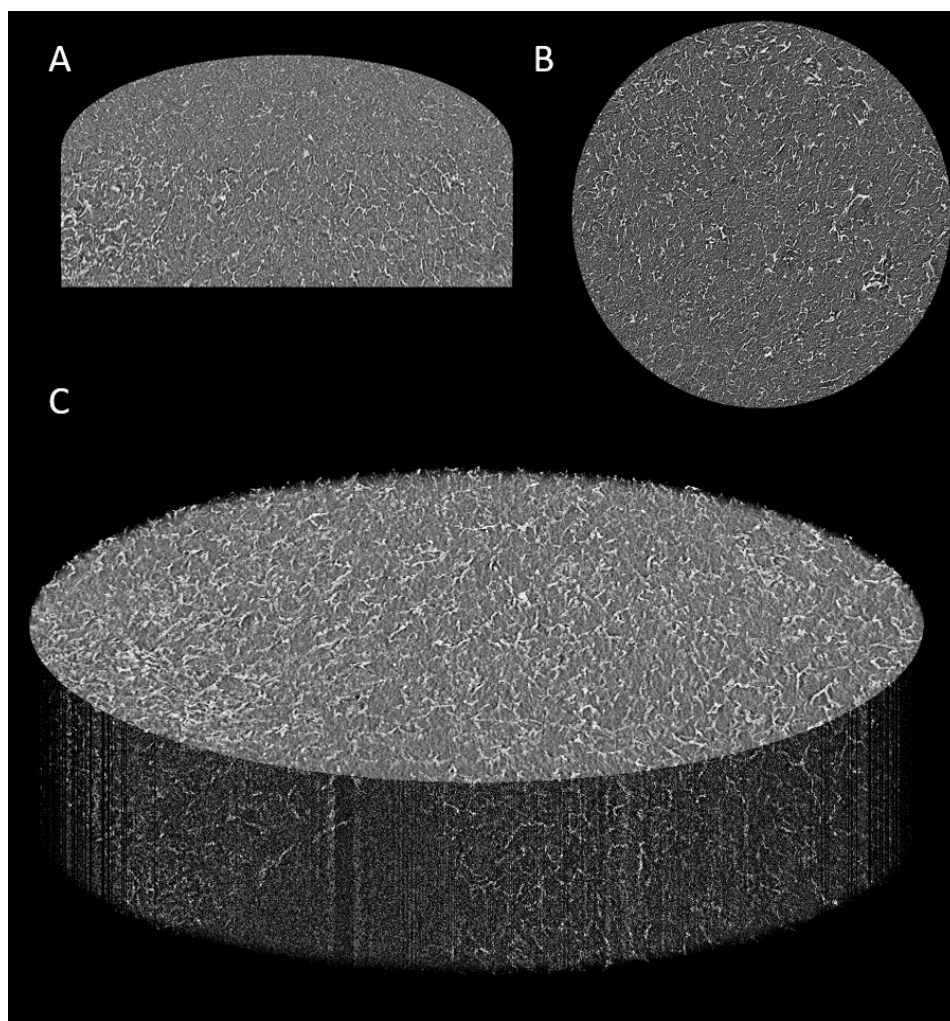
Micro CT scans of a 1% PVA aerogel showing (a) a three-dimensional representation of an orthogonal slice through the scanned section (b) a cross section of the scanned section of the gel and (c) a full three-dimensional representation of the scanned portion of the gel.
